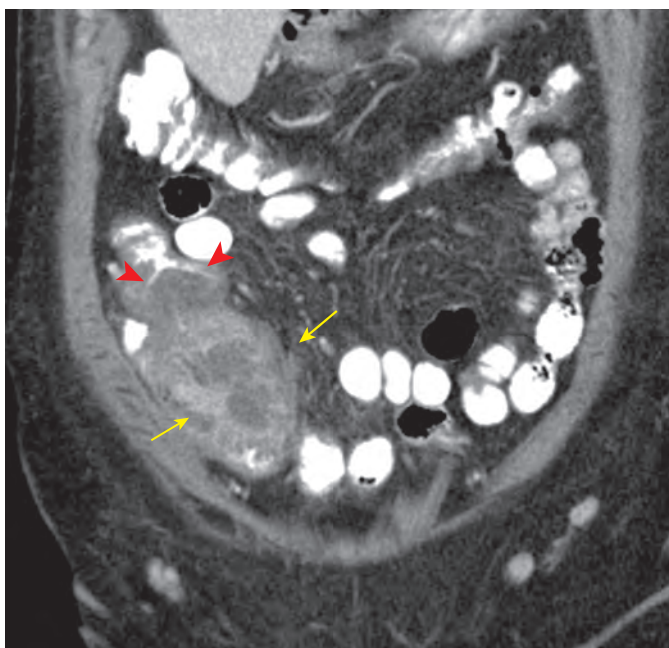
Perforated acute appendicitis with abscess. This coronal image from an enhanced CT scan shows extensive right lower quadrant inflammation and a fluid-filled abscess (arrows). Note the thickened, inflamed cecum (arrowheads).
